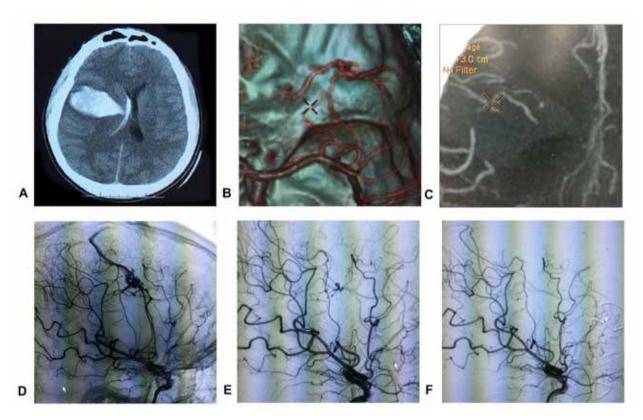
Image of Case 2 (Type II) A: Head CT showed right frontal-parietal hemorrhage into the lateral ventricle; B-C: CTA and maximum intensity projection (MIP) showed an AVM located above the intracerebral hematoma and supplied by the cerebral middle artery; D: Preoperative DSA showed that the AVM was supplied by the middle cerebral artery and that the drainage vein ascended into the sagittal sinus; E: A residual AVM was observed during resection; F: DSA after resection showed total resection of the AVM.
